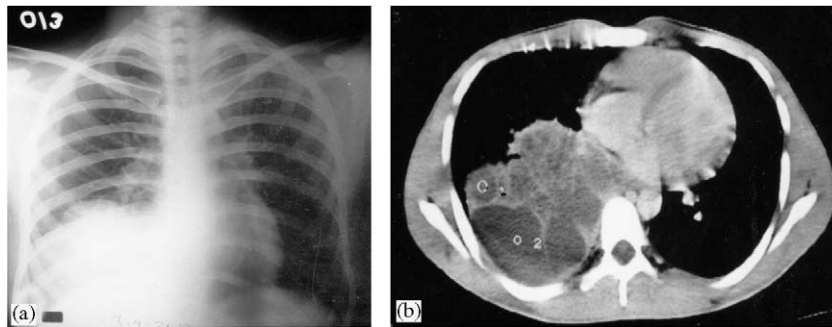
(a,b) Posterior anterior chest X-ray and thorax tomography demonstrating paracardiac multiloculated cystic mass in right lower lobe.
